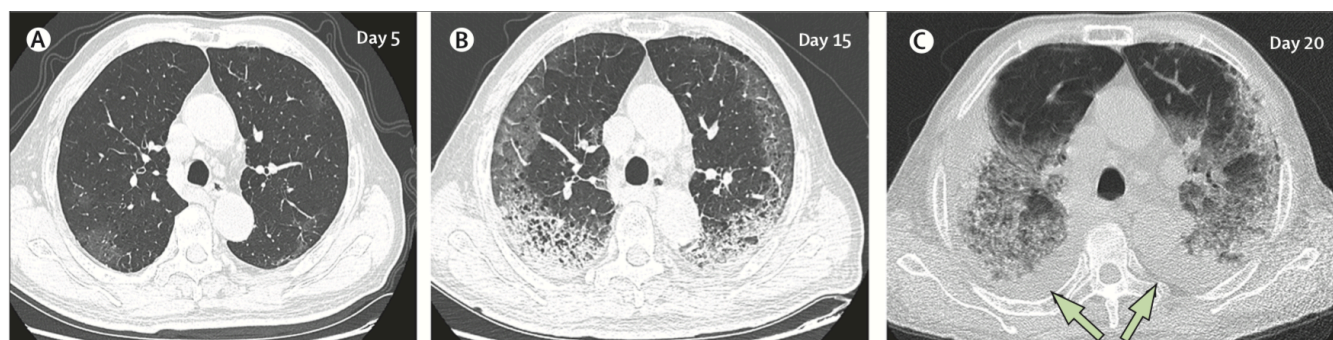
CT chest findings in COVID-19
